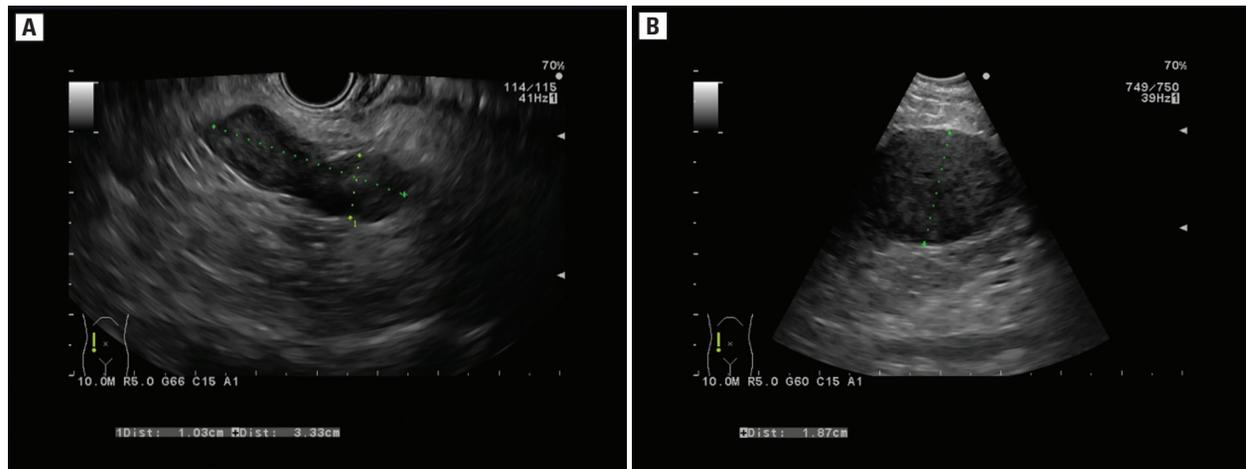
Metastatic, enlarged and hypoechoic left adrenal gland in endoscopic ultrasound (EUS) (A) and endoscopic ultrasound by use of bronchoscope (EUS-b) (B) imaging
